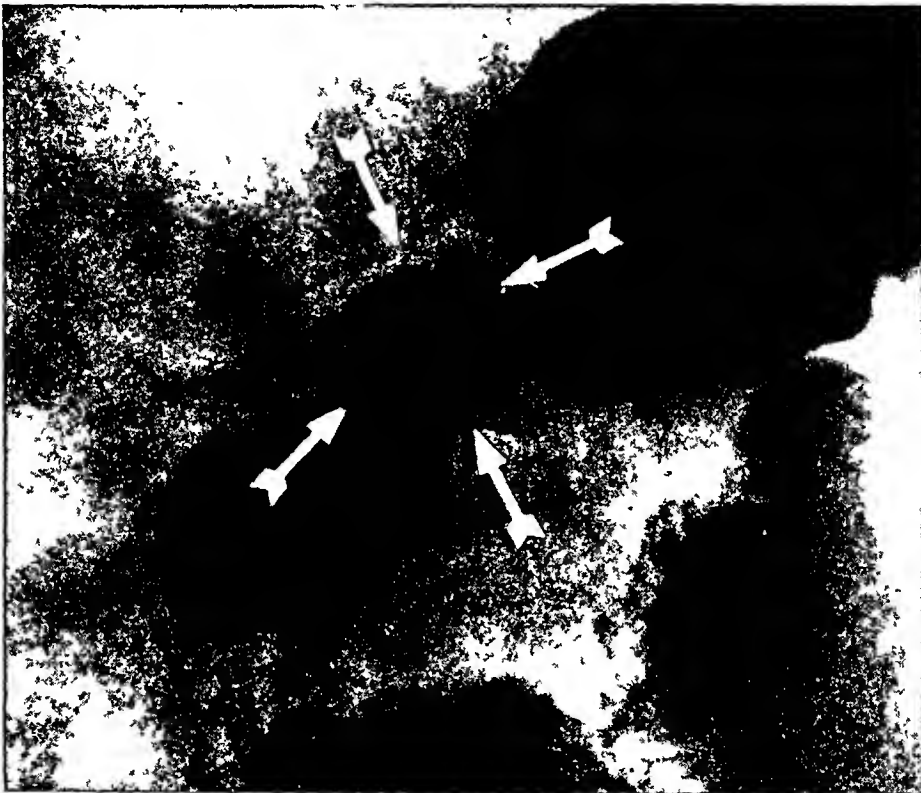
Case 2: Roentgenogram showing the large ulcer pocket.
